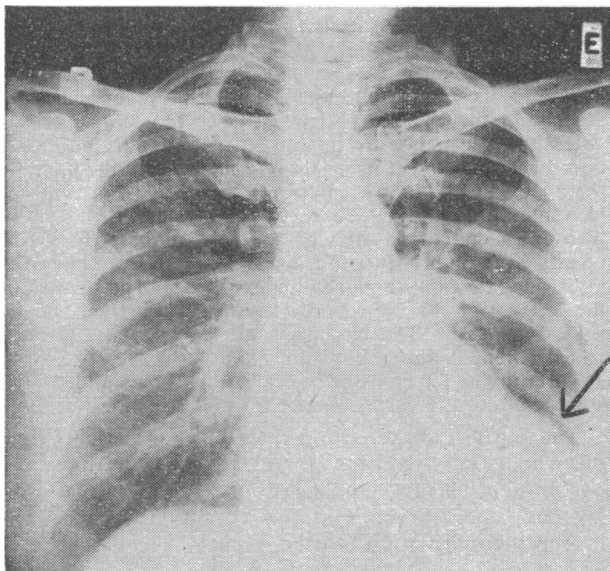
Case 1. Radiograph of chest taken five weeks after admission showing ventricular aneurysmal bulge marked by arrow.
